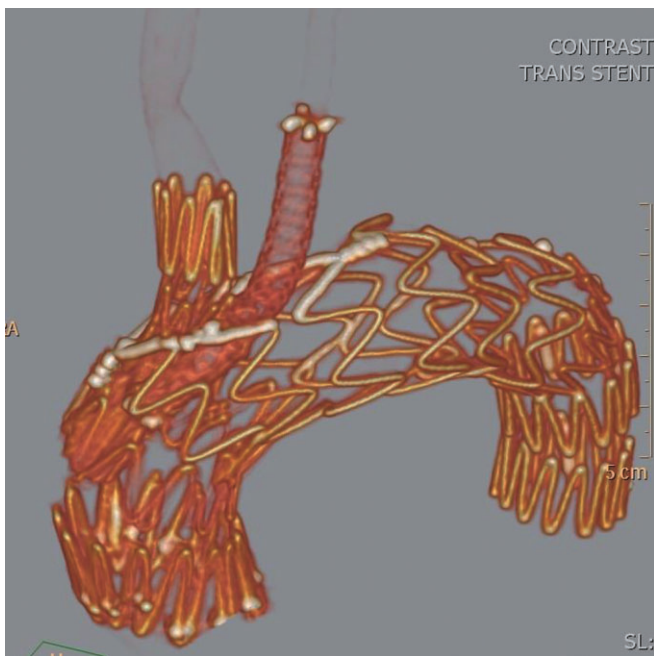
CT showing arch, stent graft with bridging stents.
